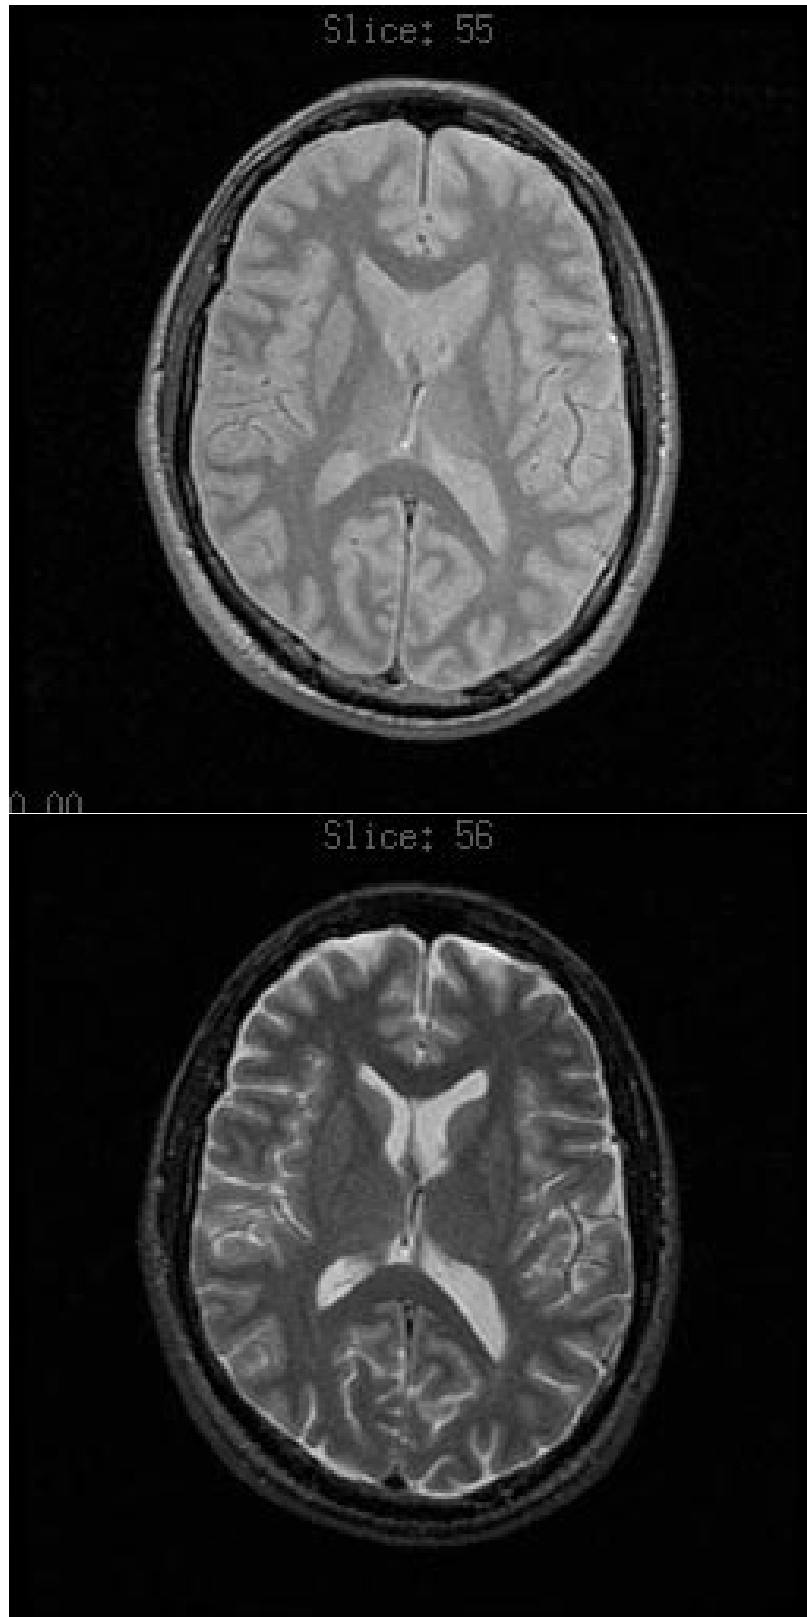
Proton-density and T2-weighted images
